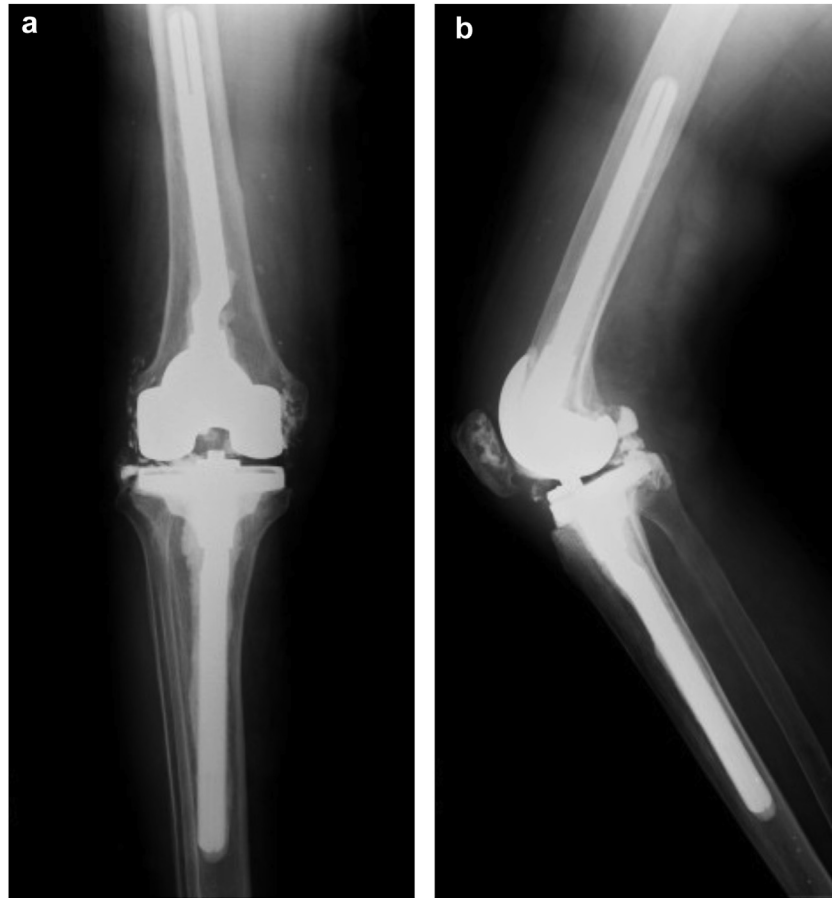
Postoperative plain radiographs after revision total knee arthroplasty. (a) Antero-posterior view; (b) lateral view. A constrained condylar knee prosthesis (Persona CCK: Zimmer-Biomet, Warsaw, Indiana) with stem extension on both the femoral component (offset, 6 mm; 12 × 135) and tibial component (offset, 3 mm; 13 × 135) was chosen.
